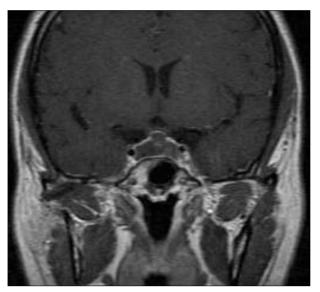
Gadolinium-enhanced T1 weighted coronal magnetic resonance image showing a large area of insufficient enhancement in the anterior pituitary consistent with pituitary infarction, abutting the left cavernous sinus.
